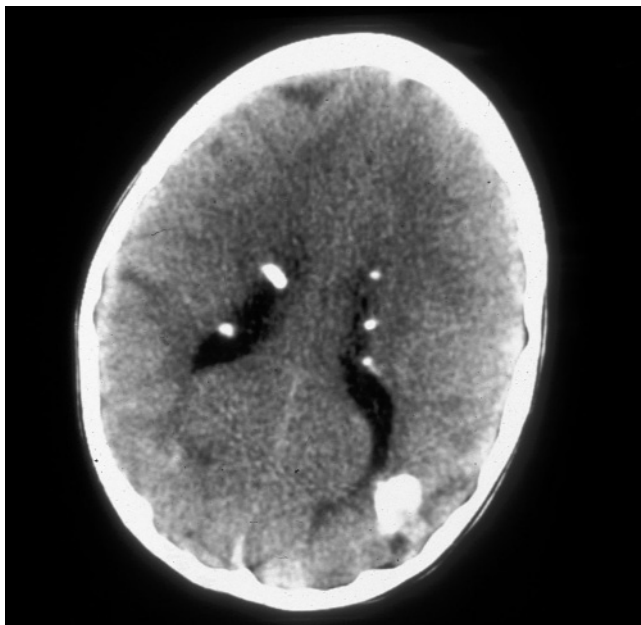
Computed tomographic scan from a child with tuberous sclerosis complex demonstrates typical calcified subependymal nodules, a large calcified parenchymal lesion, and smaller low-density cortical lesions. Reproduced with permission from Roach ES, Kerr J, Mendelsohn D, et al: Diagnosis of symptomatic and asymptomatic gene carriers of tuberous sclerosis by CCT and MRI. *Ann N Y Acad Sci* 1991;615:112-122.
